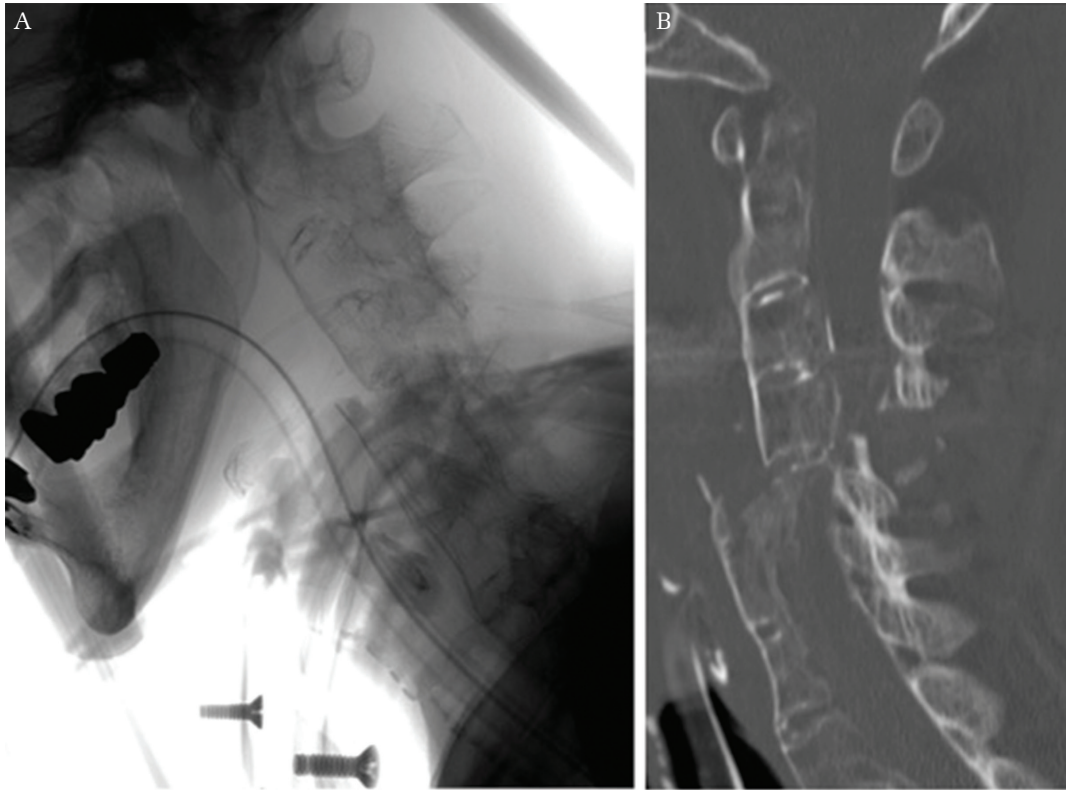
Case 4. Lateral radiography (A) and computed tomography scanning (B) show an inadequate reposition of a dislocated fracture with a halo vest.
